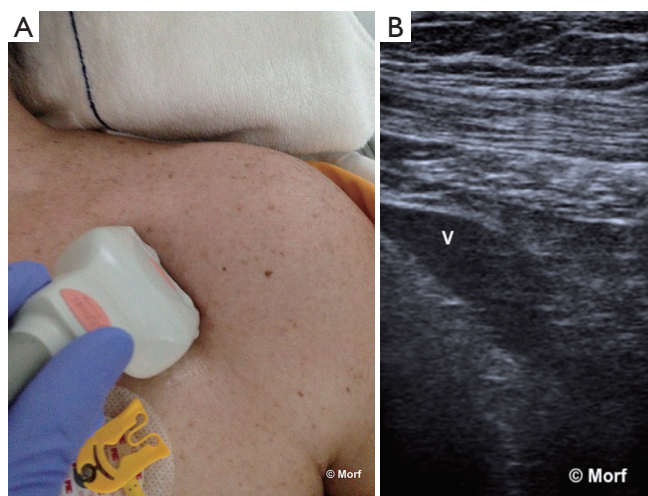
Sonographic visualization of the subclavian vein: transducer position (A), corresponding US image (B). US, ultrasound.
